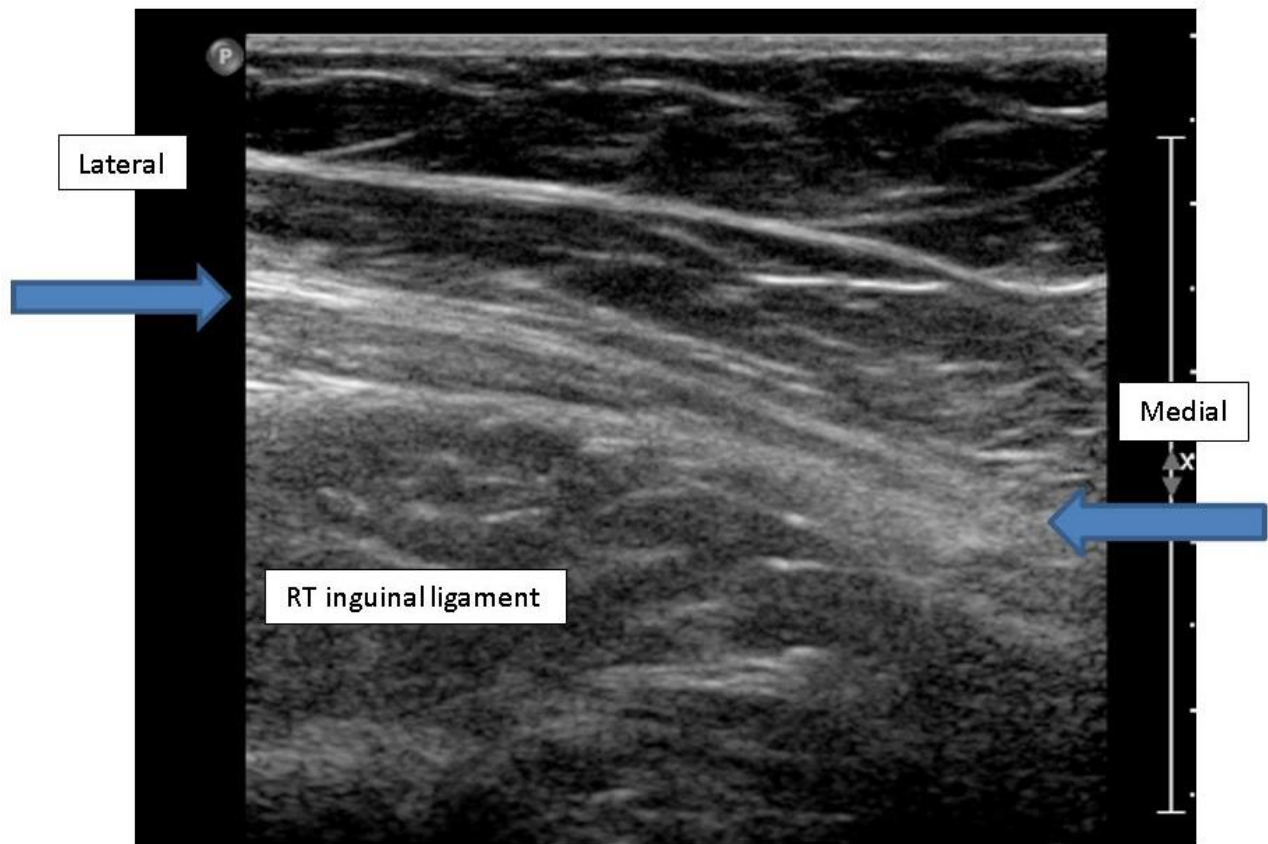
Sonographic appearance of the inguinal ligament
